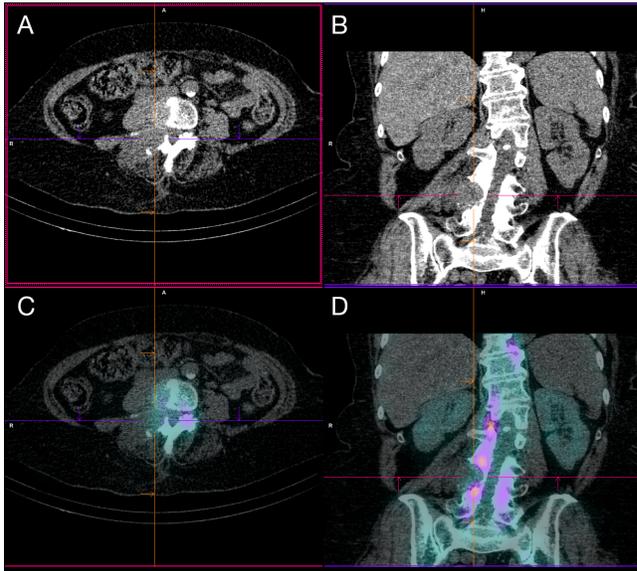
SPECT/CT taken 3 hours after IV administration of ^{99m}Tc MDP demonstrating extensive soft tissue involving L4 confirming the diagnosis of metastatic sarcoma. A) and B) Axial and coronal CT soft tissue reformats. C) and D) Axial and coronal fused SPECT/CT.
